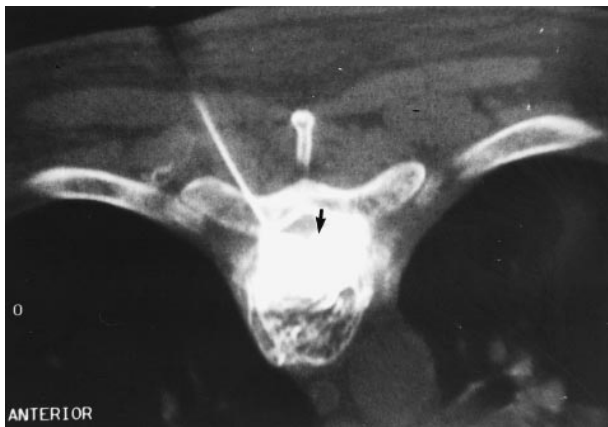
Axial CT scan at the level of the maximal epidural soft-tissue component of the hemangioma taken during injection of contrast medium through the needle positioned into the vertebral body. Note the excellent opacification of the epidural soft tissue on either side of midline (arrow).
